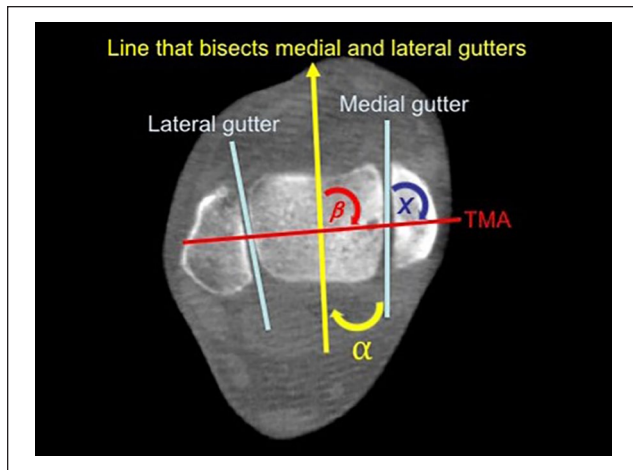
Axial slice of a computed tomography scan taken 4 mm below the tibiotalar joint line. Lines were drawn along the medial and lateral gutters. The gutter lines were then bisected. These lines were then referenced against the transmalleolar axis (TMA). Angle α represents the difference between the medial gutter line and the line bisecting both gutters. Angle β represents the angle between the line bisecting both gutters and the TMA. Angle X represents the angle between the medial gutter line and the TMA.
